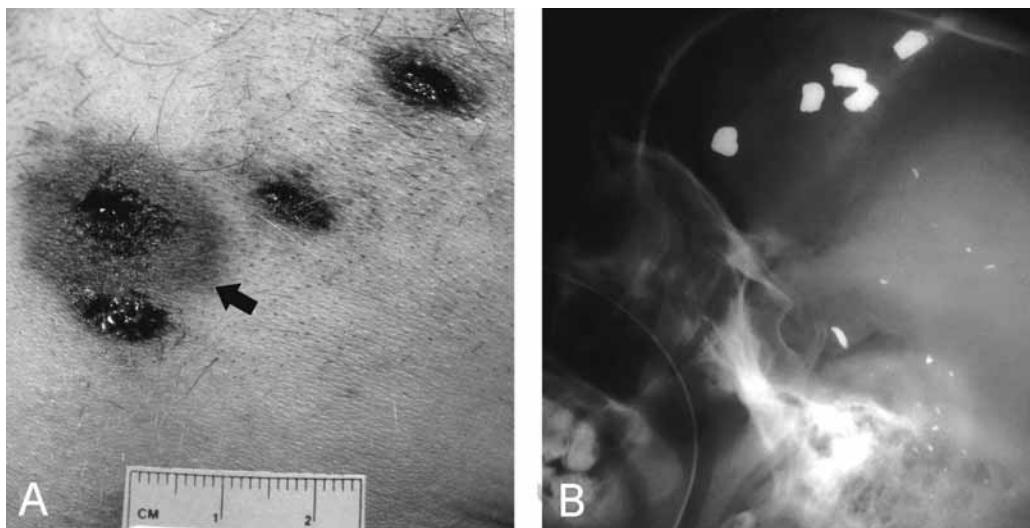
Discharge of handgun more than once through same entry site; homicide. (A) Four hard contact gunshot wounds, posterior neck. One entry (arrow) shows more prominent soot deposition and bruising. (B) Skull radiograph. Five bullets.
